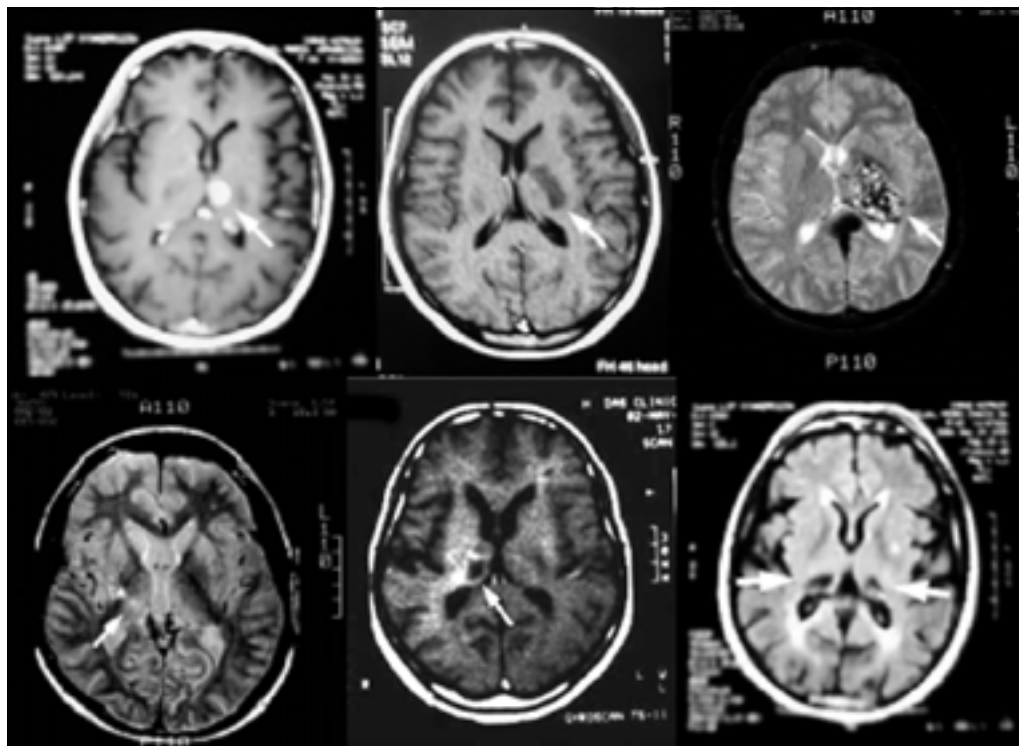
MRI findings in Patients 1 to 6. The arrows indicate the lesions described in Table 1.
